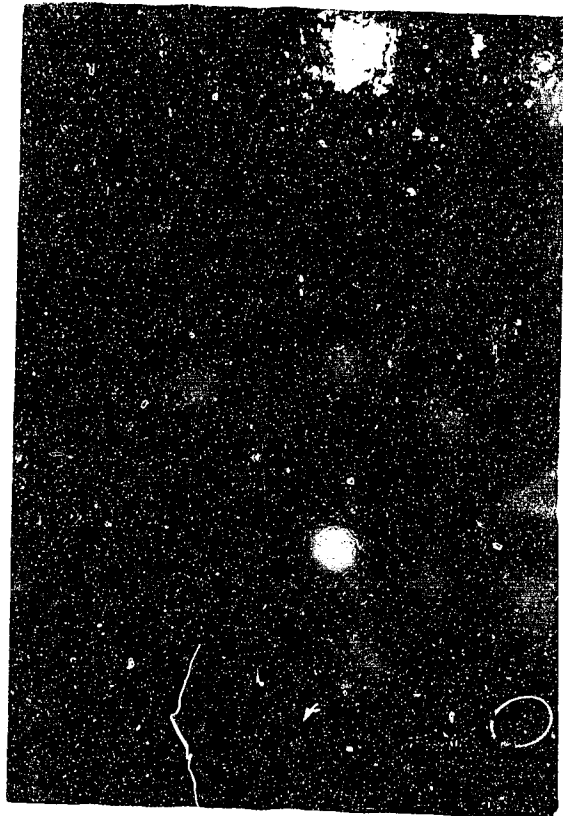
An x-ray of the acetabulum oriented sideways (lateral at the top to medial at the bottom). The arrow indicates the deepest portion of the acetabular rim notch.
